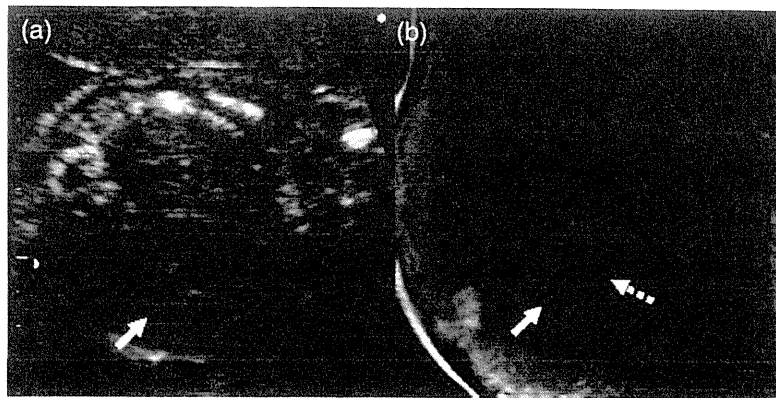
(a) Coronal section of fetal thorax (4-chamber view) at 22 weeks' gestation by ultrasound. The right lung could not be detected and the heart (solid arrow) was shifted to the right side. The cardiothoracic area ratio was increased to 38%. (b) MRI (half Fourier single-shot Turbo spin echo) performed at 35 weeks' gestation. Right lung was absent and the mediastinum (solid arrow) was shifted toward the right side. Dotted arrow indicates left lung
